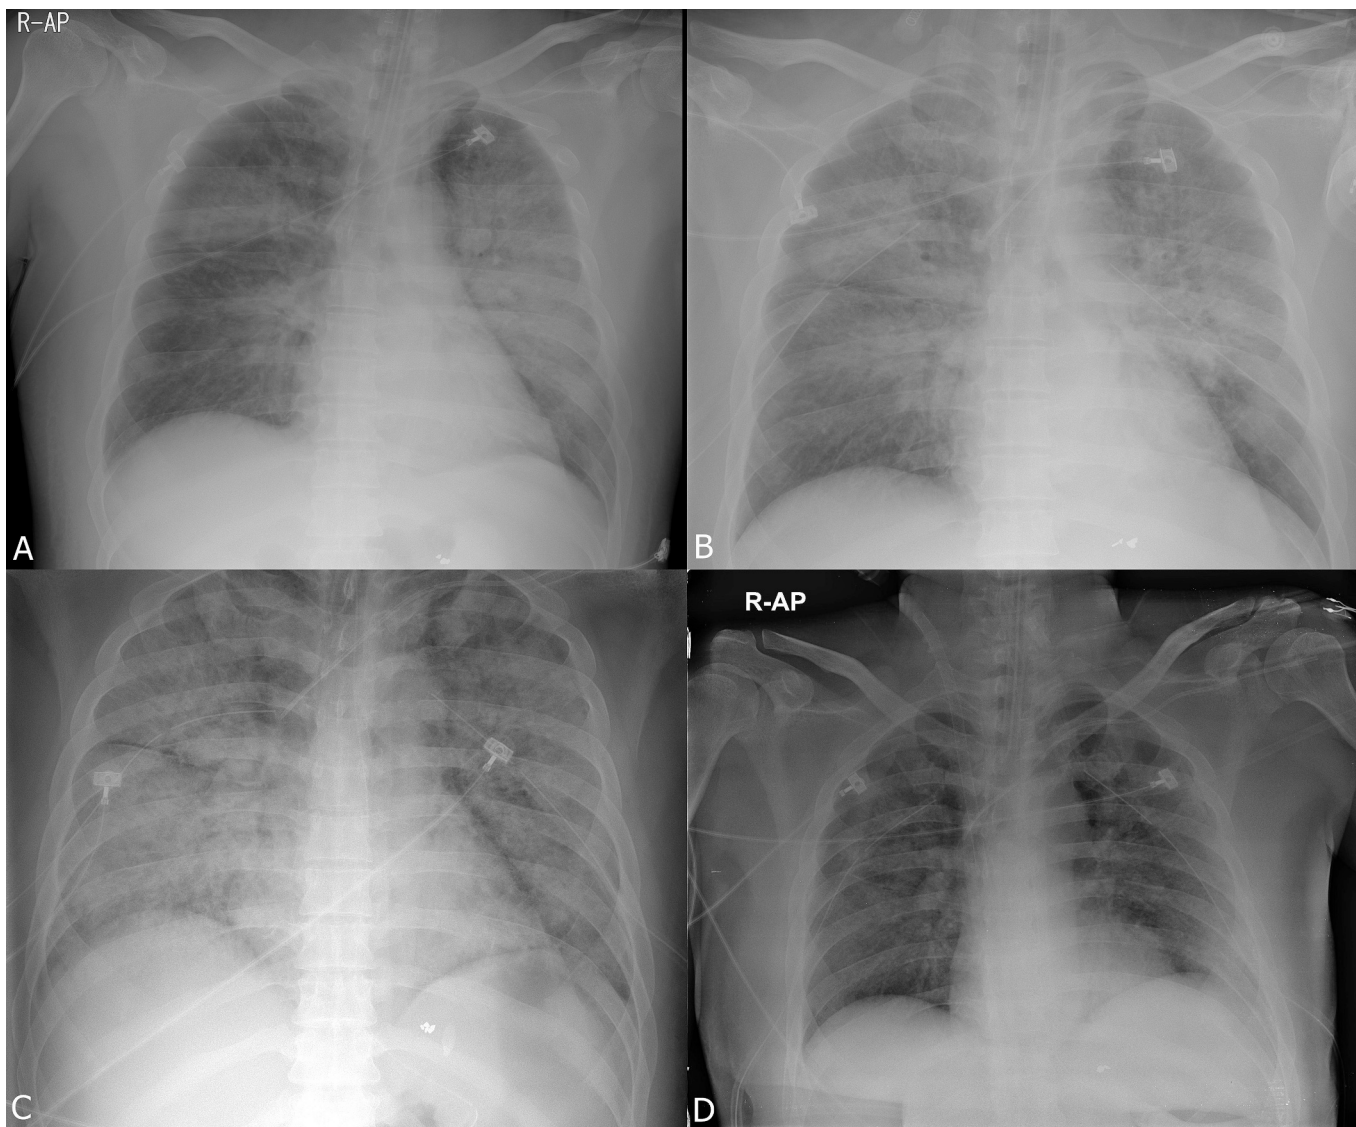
(A) On the third postoperative day, the patient complained of worsening dyspnea even at rest, and a follow-up chest X-ray showed bilateral lung infiltration. (B) On the fourth postoperative day, his chest X-ray showed progressive lung infiltration and both pleural effusions. (C) On the seventh postoperative day, his chest X-ray showed progressive lung infiltration. (D) The lung infiltration on the chest X-ray rapidly resolved after six days on ECMO support.
